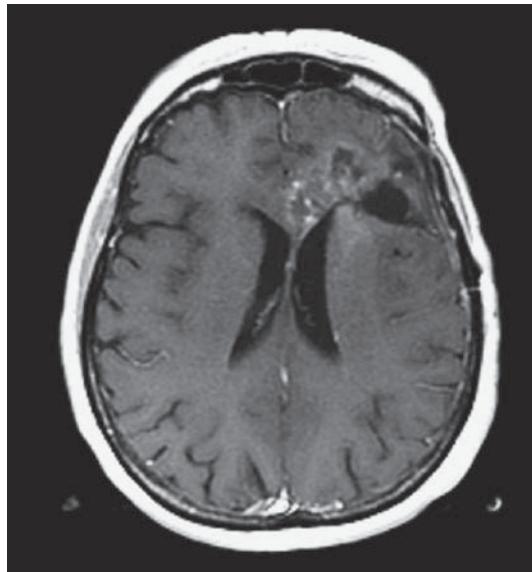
Postgadolinium T1 MRI of a recurrent glioblastoma before (A) and after (B) administration of bevacizumab. Note the decreased enhancement and mass effect.
